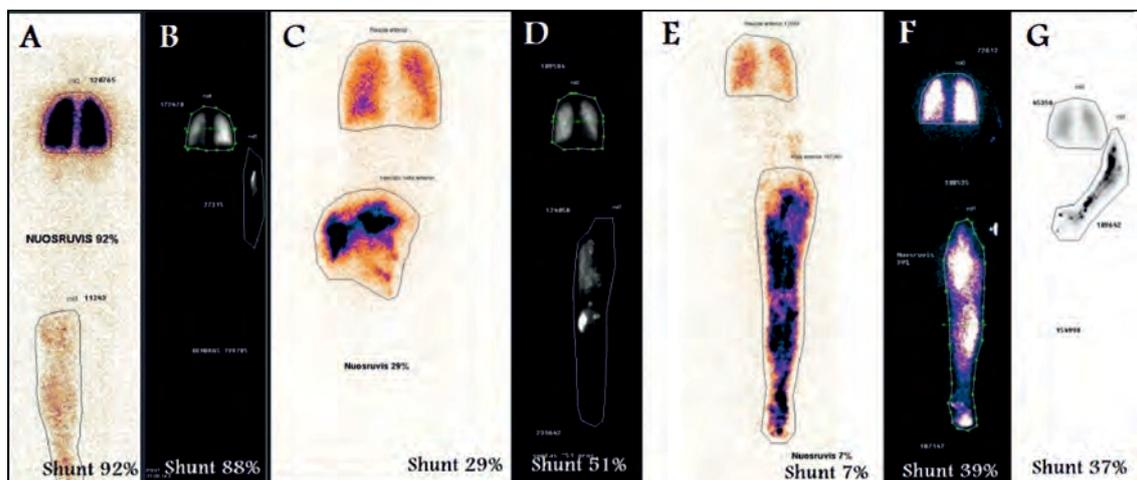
Presentation of arteriovenous malformations on transarterial lung perfusion scintigraphy A, D, E, and F show AV shunting of various degrees in the lower extremities; B and G, in the upper extremities; and C, in the gluteal region.
